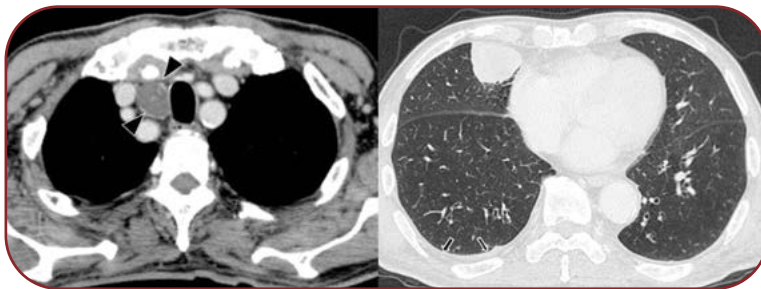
Chest computed tomography scan taken at the time of presentation showing a large mass in the middle lobe of the right lung – mediastinal lymph node swelling (arrow heads) and a small amount of ipsilateral pleural fluid (arrows) are also visible
